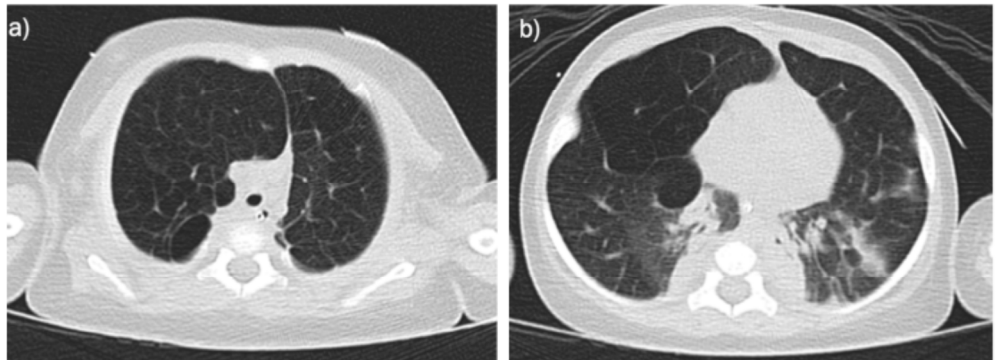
Case 3: Axial chest CT images of the (a) upper and (b) lower lobes at 2 months of age demonstrate upper lobe hyperinflation with sparse pulmonary vascular markings and bibasilar medial atelectatic changes.
